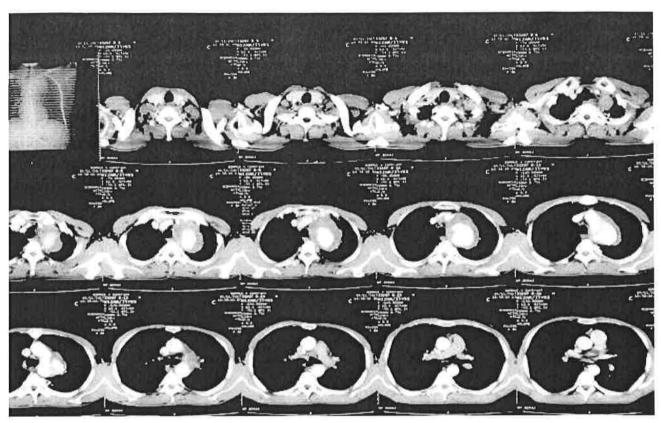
Multiaxial contrast CT scan of the chest showing strong homogenous enhancement of the lumen with eccentric non-enhancing hypodense area represents thrombus suggestive of aortic arch ancurysm with mural thrombus.
